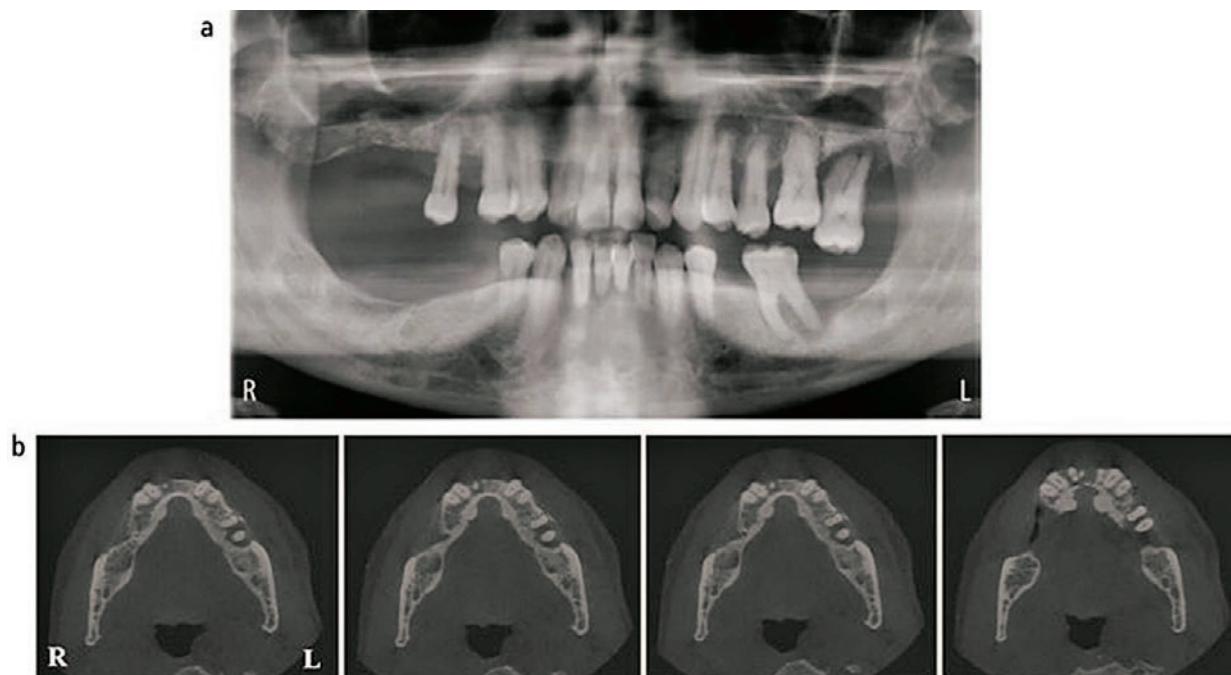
Orthopantomogram with potential implants in the lower jaw (a); CBCT showing a significant bone loss, especially in the bottom right section (b)
